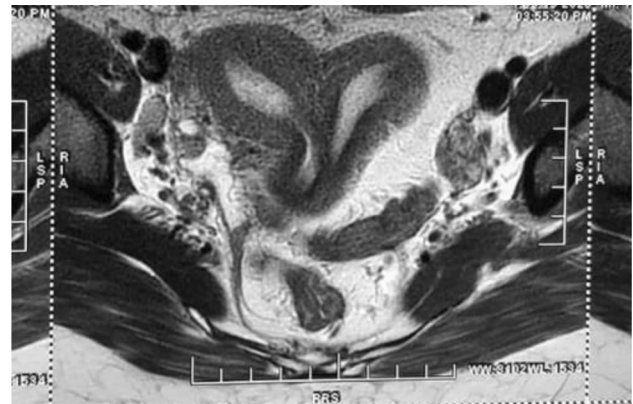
MRI pelvis was suggestive of uterus didelphys with obstructed right hemivagina and obstructed mucopurulent material in right uterus and right hemivagina
